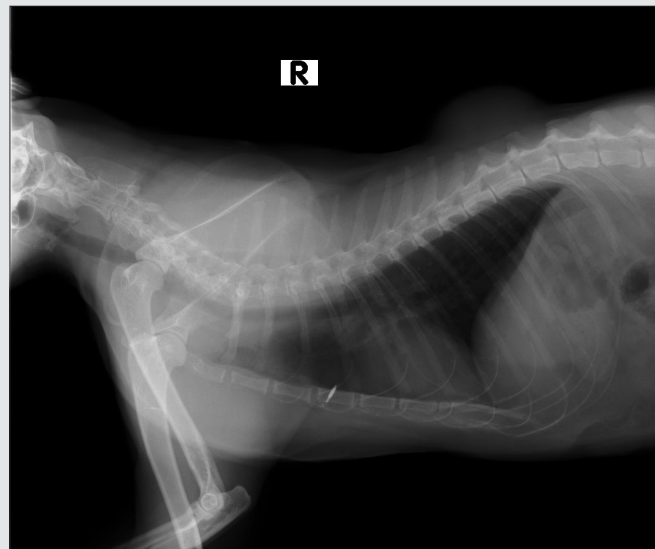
Latero-lateral chest radiographic plate, in which you can see a radiopaca structure between T10-T12 (white arrow) in the dorsal region not attached to the bone tissue.
